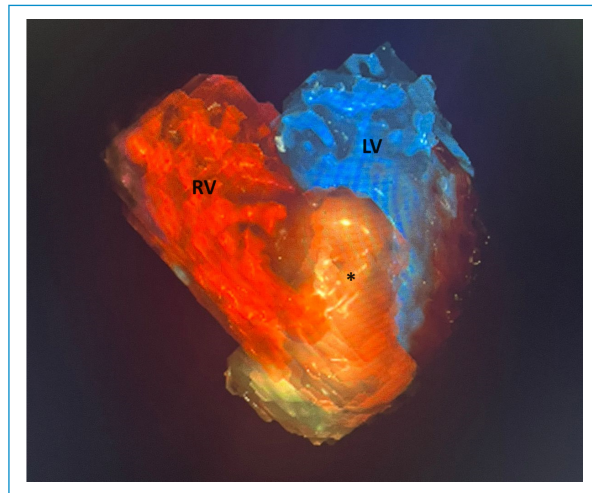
3D MRI reconstruction. *Fibroma. RV: right ventricle; LV: left ventricle.
